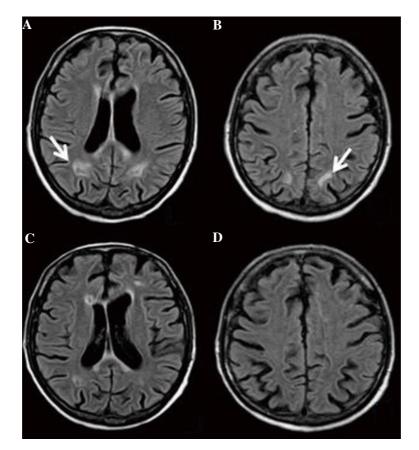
Pre and post-treatment axial fluid-attenuated inversion recovery MRI. A and B: Pre-treatment axial fluid-attenuated inversion recovery MRI reveals altered signal intensity in the parietal subcortical white matter (white arrows). C and D: Post-treatment axial fluid-attenuated inversion recovery MRI reveals partial resolution of subcortical white matter abnormality.
